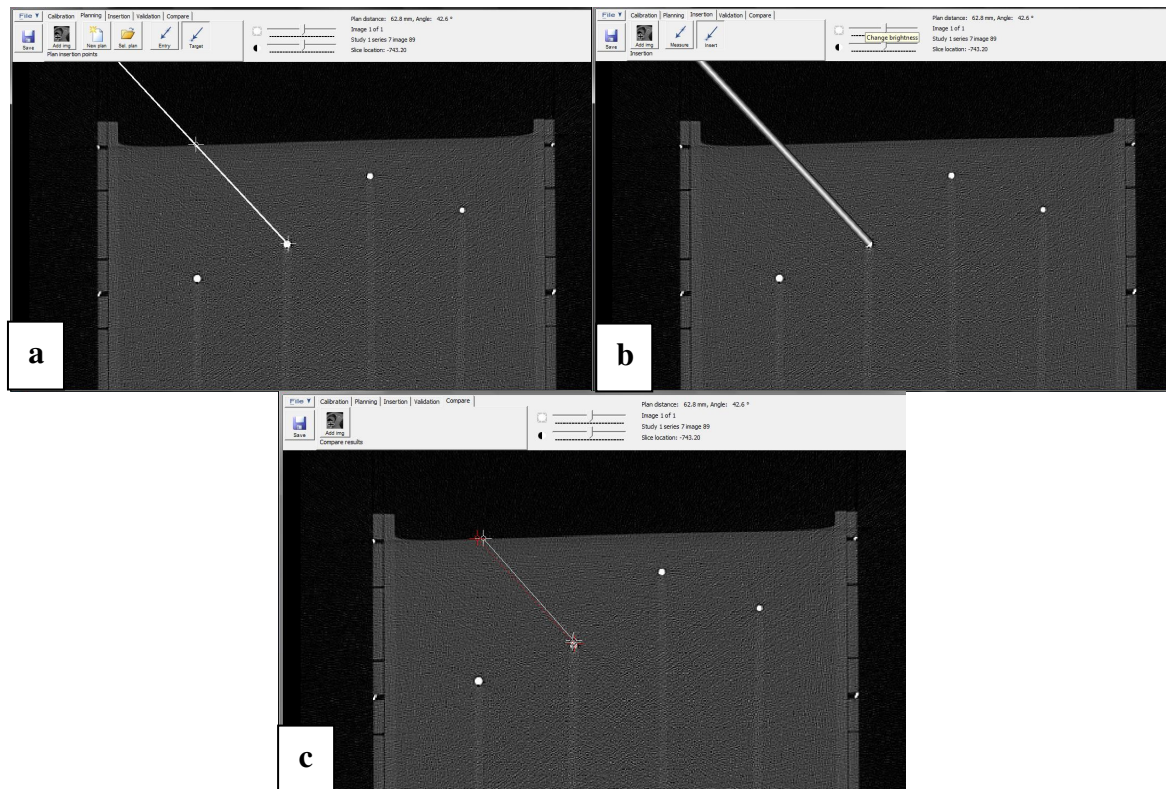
The graphical interface software of CT image overlay; a) planning b) guiding path c) insertion and target point error
